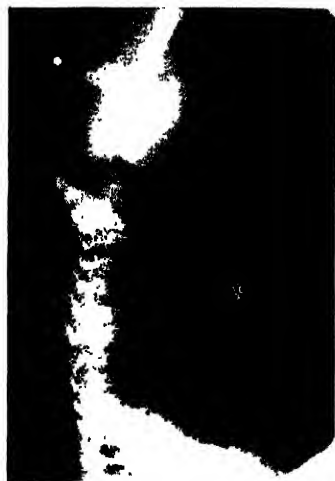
X-ray of neonate while held upside down to show gas in rectum. Anal dimple marked by piece of shot. (Graham Arth, Bristol.)
